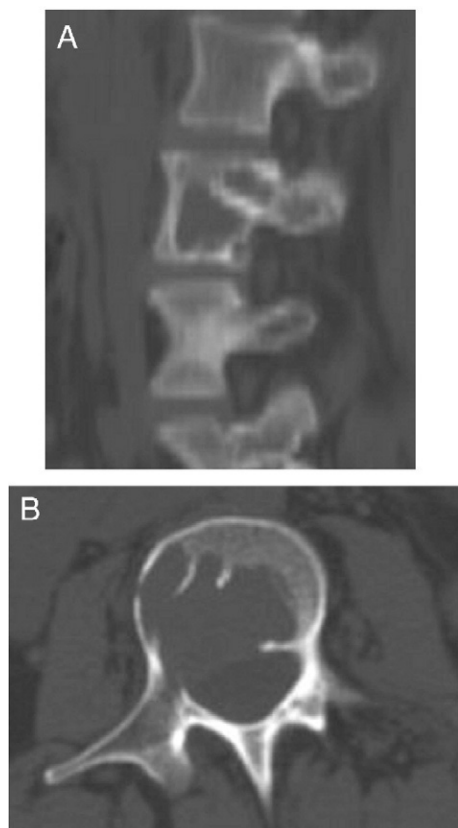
Preoperative lateral (A) and axial (B) computed tomographic images of the lumbar spine noting extensive tumor involvement of the L3 vertebral body, right pedicle, and possible epidural space.
